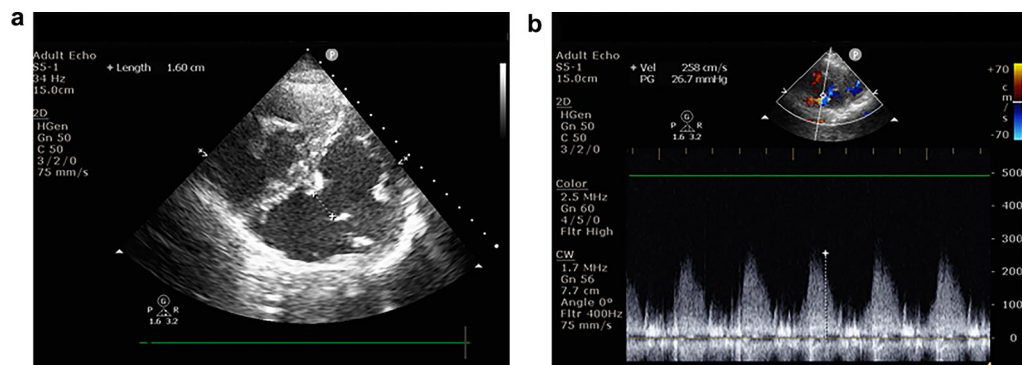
TTE of the parasternal short-axis view on the 22nd day after AMI. a 2D image revealed IVSD with multiple lacerations on both the left and right ventricular sides. b PW revealed the peak systolic flow velocity at one of the lacerations of the right ventricular side of the IVSD was 258 cm/s
